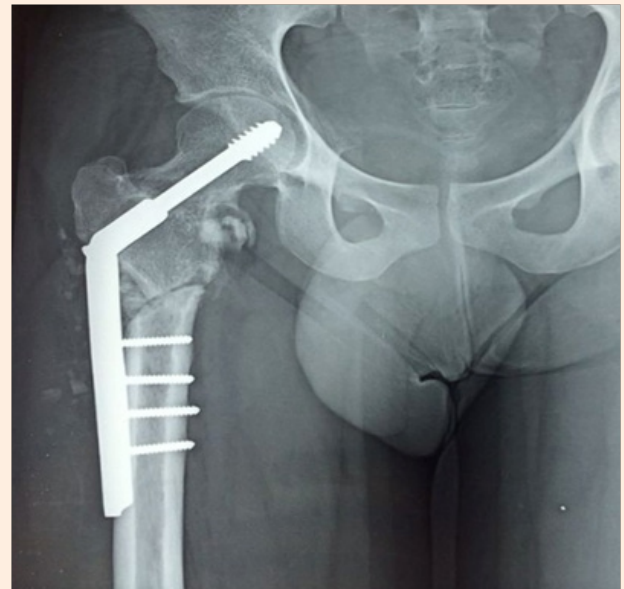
Post operative radiograph at 1 year of follow up.
